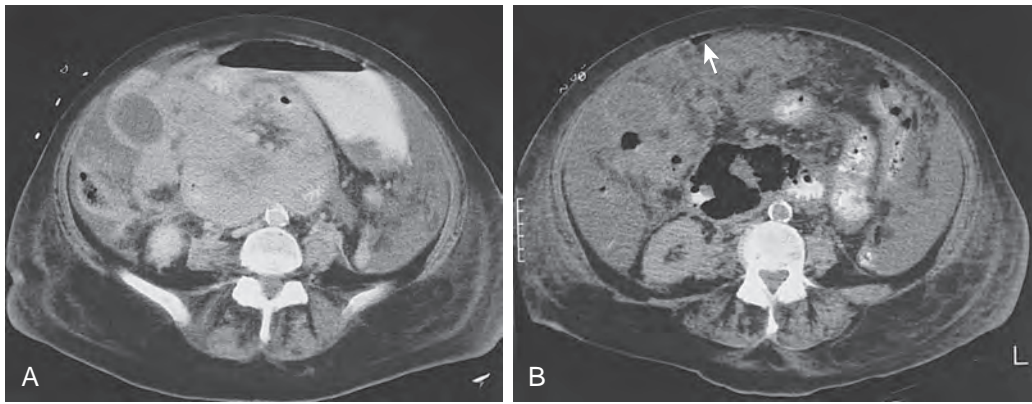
Response of duodenal lymphoma to chemotherapy. A. CT scan shows a conglomerate mass of adenopathy surrounding the mesenteric vessels. The duodenum is encased by this mass. B. Repeat CT scan after two cycles of chemotherapy shows multiple tiny collections of gas in the duodenal wall as a result of rapid tumor lysis and mural necrosis. A tiny amount of free air (arrow) is seen in the peritoneal cavity. This patient had developed clinical signs of peritonitis.
